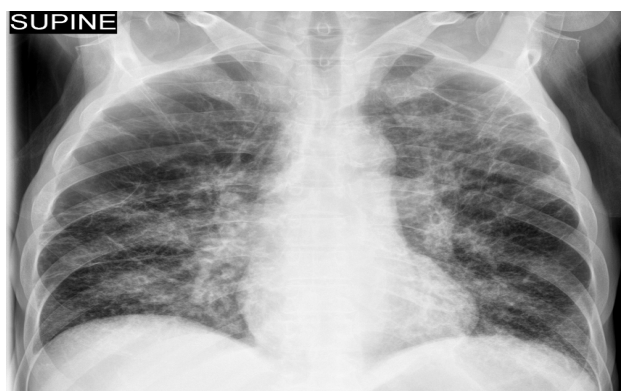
Chest X-Ray showing severe COPD and no free air under the diaphragm.
